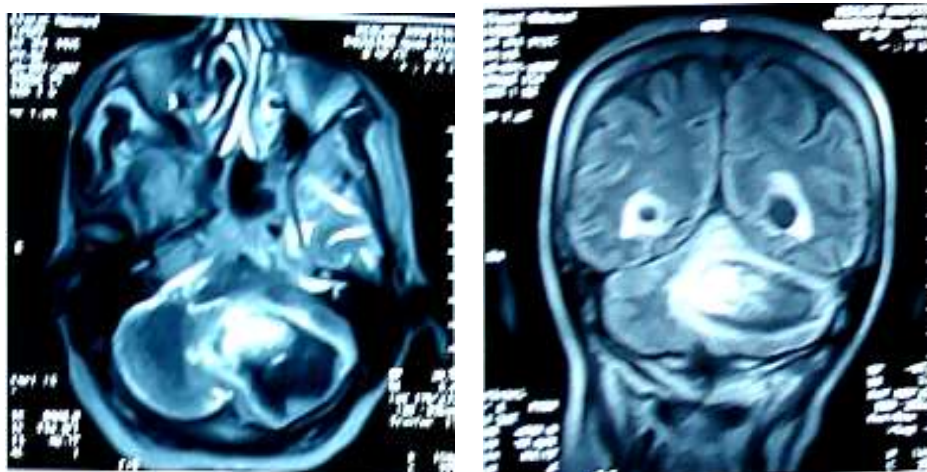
MRI in axial T2WI (A) and coronal FLAIR sequence (B) showing left cerebellar hemisphere hematoma at different stages
